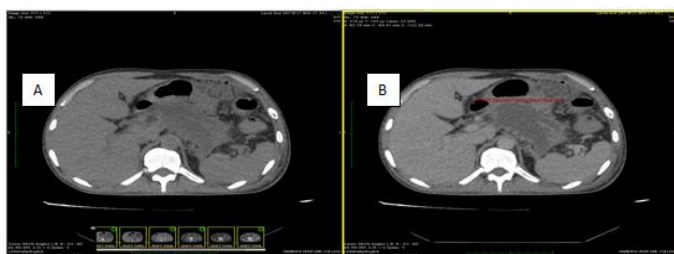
CT Axial image shows ANC in unenhanced phase (A), parenchymal phase (B) phase. ANC, acute necrotic collections
